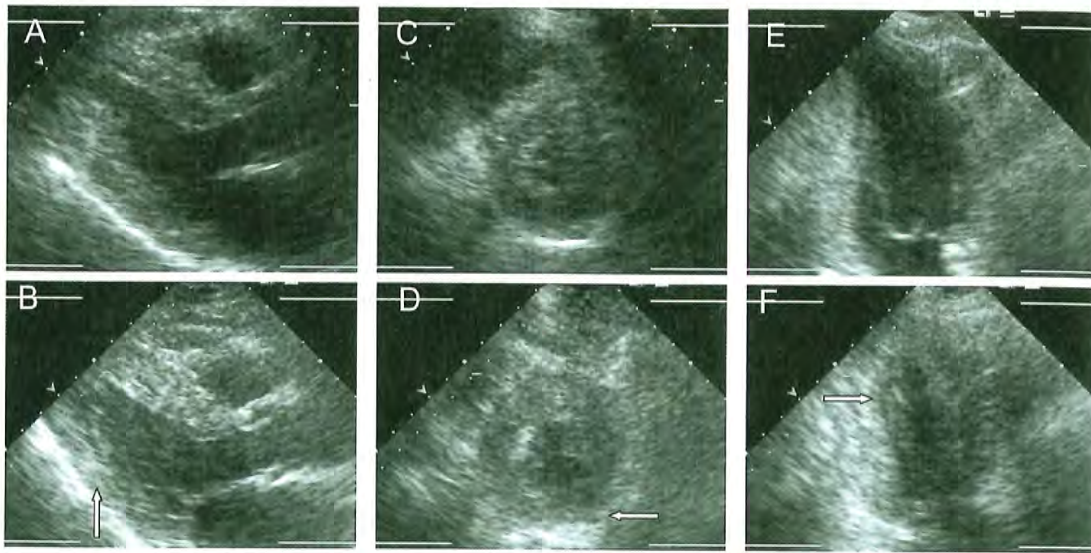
Stress echocardiogram demonstrating inferior-posterior hypokinesia with exercise (arrows). A. Parasternal long-axis rest. B. Parasternal long-axis stress. C. Parasternal short-axis rest. D. Parasternal short-axis stress. E. Apical two-chamber rest. F. Apical two-chamber stress. (Courtesy of Noninvasive Cardiac Laboratory, Brigham and Women's Hospital, Boston, MA.)
